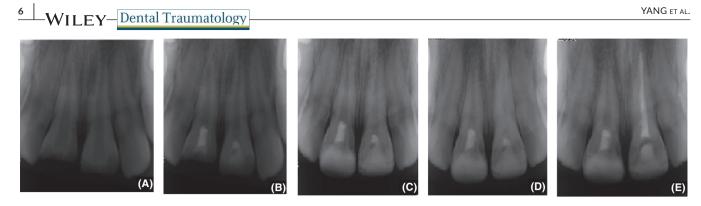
An example of a case with an unfavourable outcome involving a 7-year-old girl with complicated crown fractures in the right and left central incisors. A, Preoperative radiograph. B, Follow-up radiograph at 3 mo after CH partial pulpotomy. A calcific bridge can be seen. C, Follow-up radiograph at 6 mo. The roots are longer, and the dentin is thicker. D, Follow-up radiograph at 12 mo. Abnormal canal calcification has occurred in the left incisor. In the right incisor, the apical foramen appears smaller and the periapical region is normal. E, Radiograph after completion of root canal therapy for the left incisor
